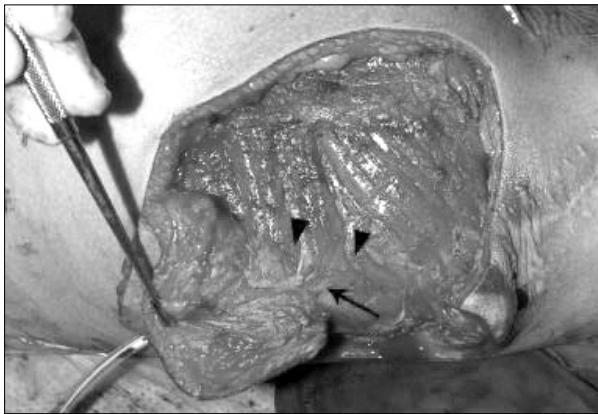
Elevation of the flap (Patient 3). The flap was elevated from the distal side along with underlying deep fascia. When the elevated end of the flap reaches the marked portion of the pedicle, meticulous dissection with frequent reconfirming of pedicle with Doppler probe was done (arrow-perforator vessels, arrow head-lateral margin of the gluteus maximus muscle).
